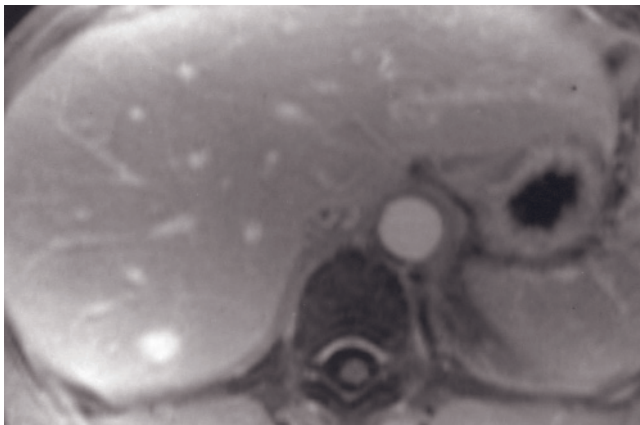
Small hemangiomas, Type 2 enhancement. T2-weighted fat-suppressed ETSE (a), SGE (b), and immediate (c) and 5-min (d) postgadolinium SGE images. A 1-cm hemangioma is present in the right lobe that is high in signal intensity on T2-weighted image (arrow, a) and low in signal intensity on T1-weighted image (arrow, b), demonstrates peripheral nodular enhancement on early image (arrows, c), and is uniformly homogeneous and moderately high in signal intensity on delayed image (d). T1-weighted SGE (e), immediate (f) and 90-s (g) SGE images in a second patient show similar findings for a small hemangioma (arrow e).
